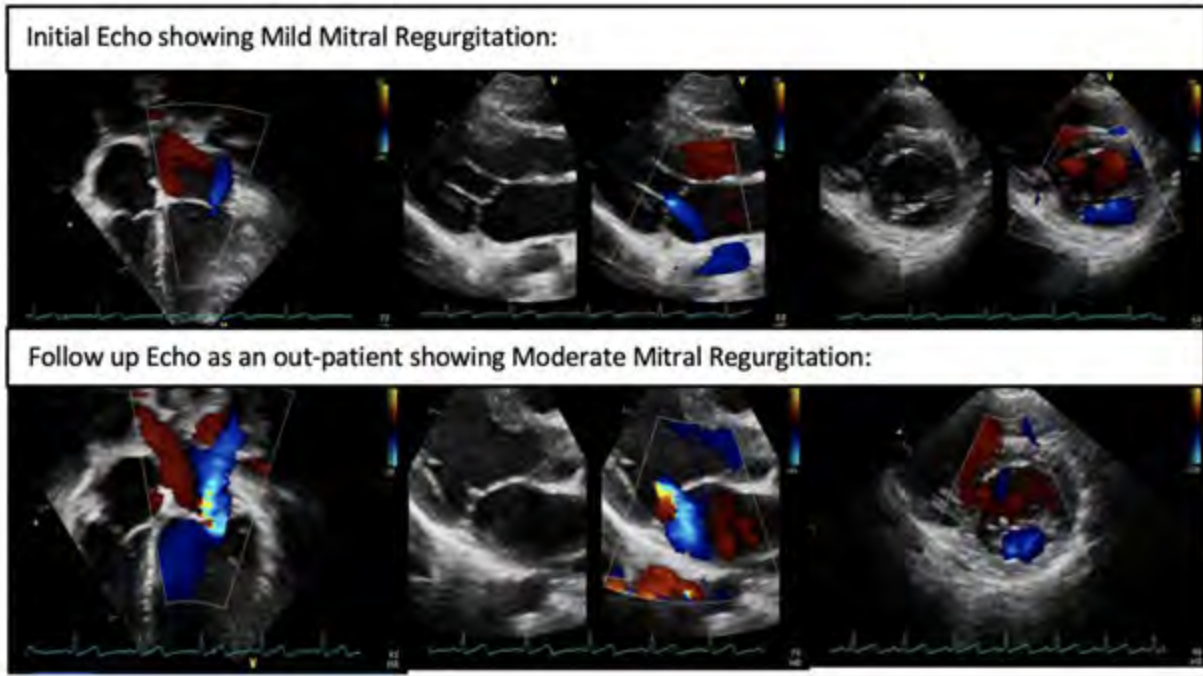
Echocardiogram Images
